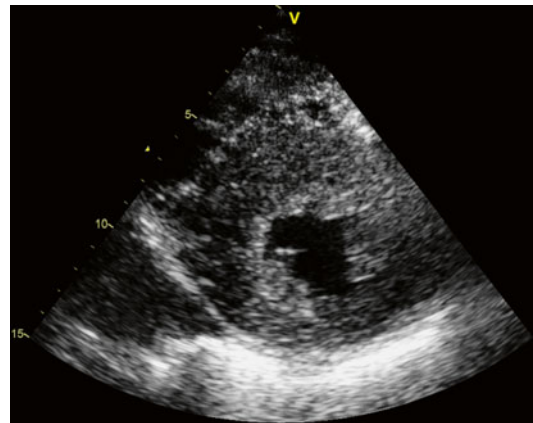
Parasternal short-axis ventricle view
